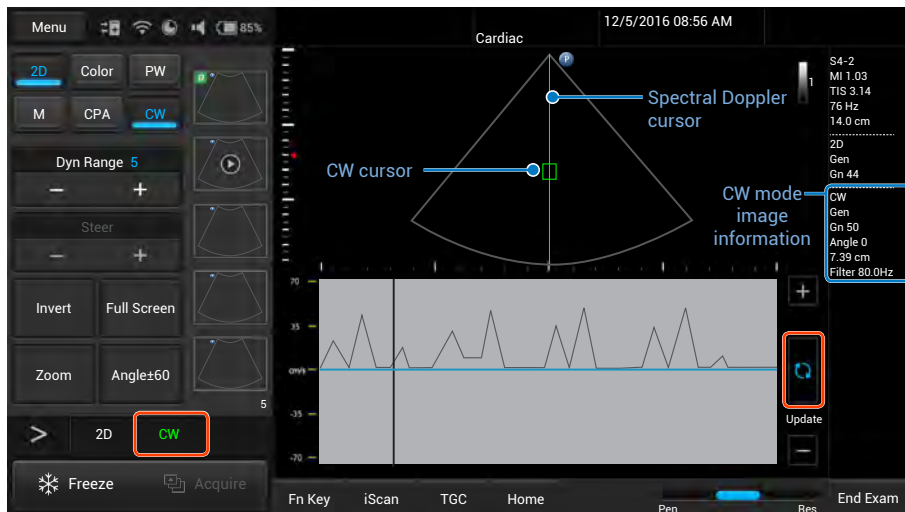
CW Doppler mode real-time scan
